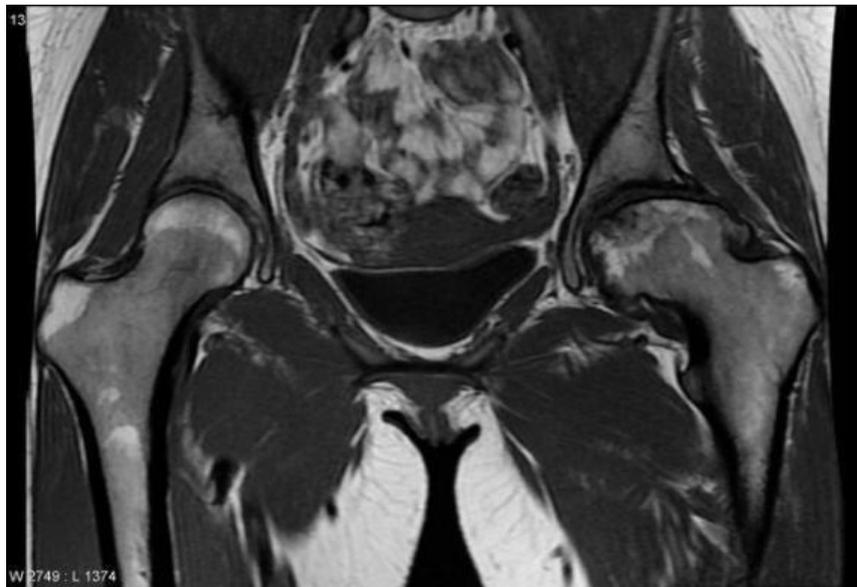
MRI of patient S.A., born in 1981, No. IB 199/61, with stage II ANFH .
